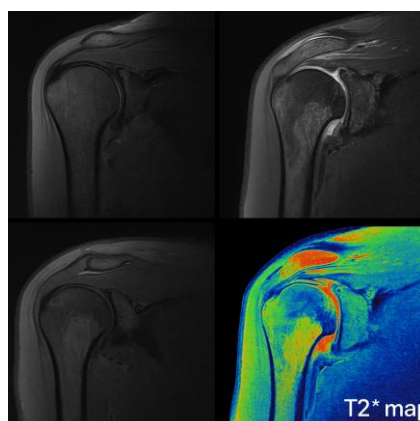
MRI of the shoulder showing supraspinatus tendinopathy with corresponding T2* quantitative map.
